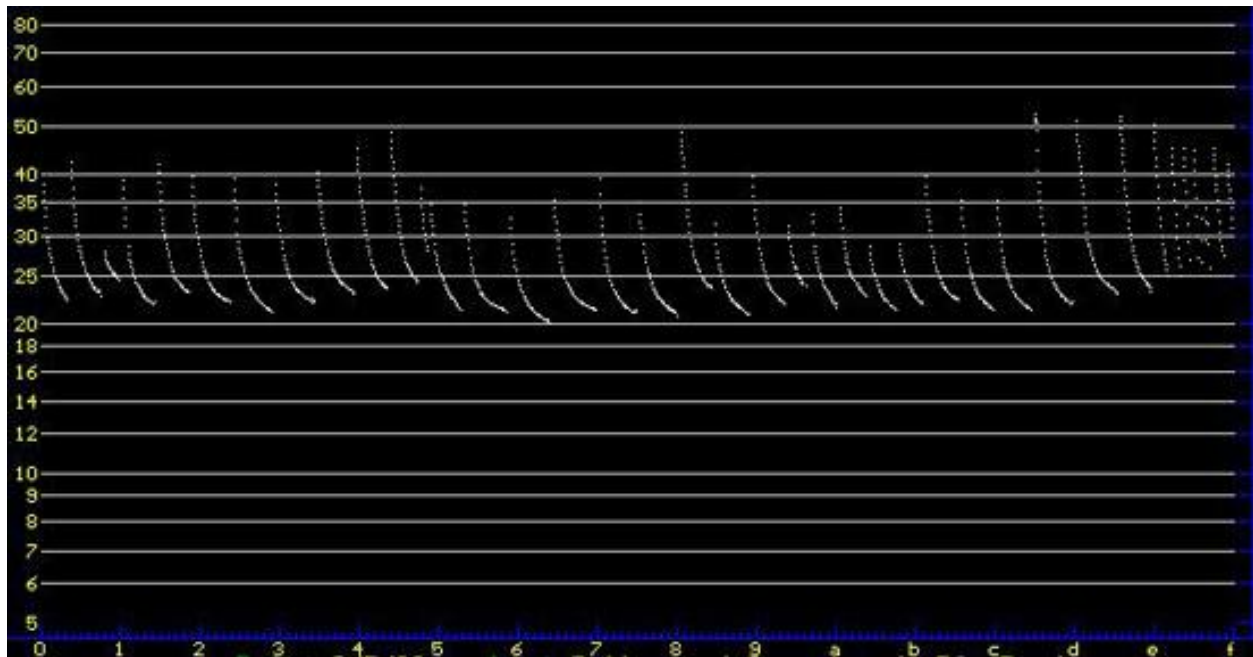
Sonogram of a silver haired bat screech, which detected a prey at the end.
